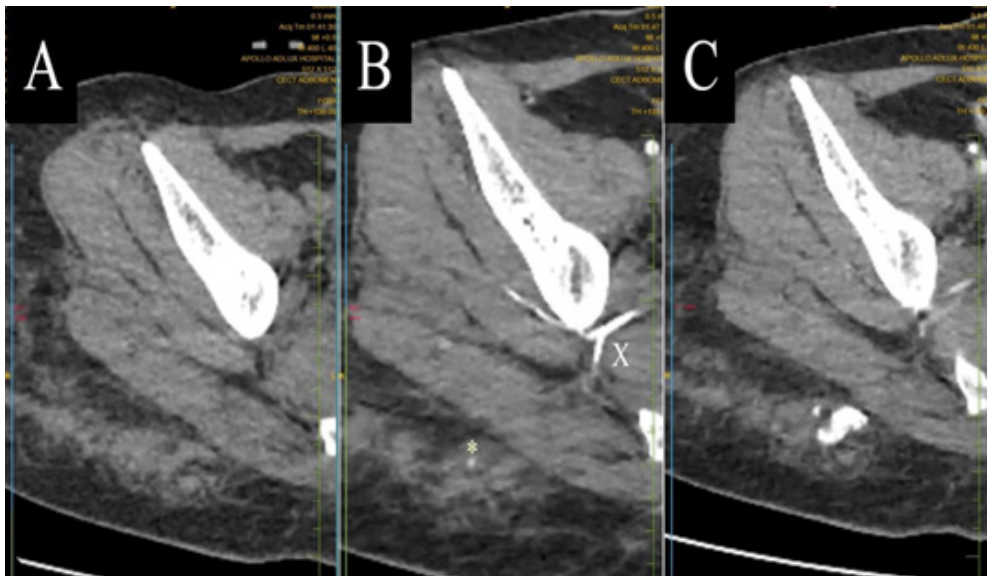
Figure 2A (Plain) CT image of the right gluteal region shows fat stranding. Figure 2B (Arterial phase) Branches of the gluteal artery (X) are well seen along with contrast extravasation (*). Figure 2C (Venous phase) shows active contrast blush suggestive of ongoing bleeding.
